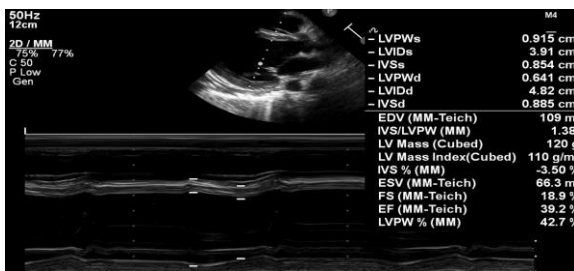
Echocardiography post catheter ablation, ejection fraction 39,2%
